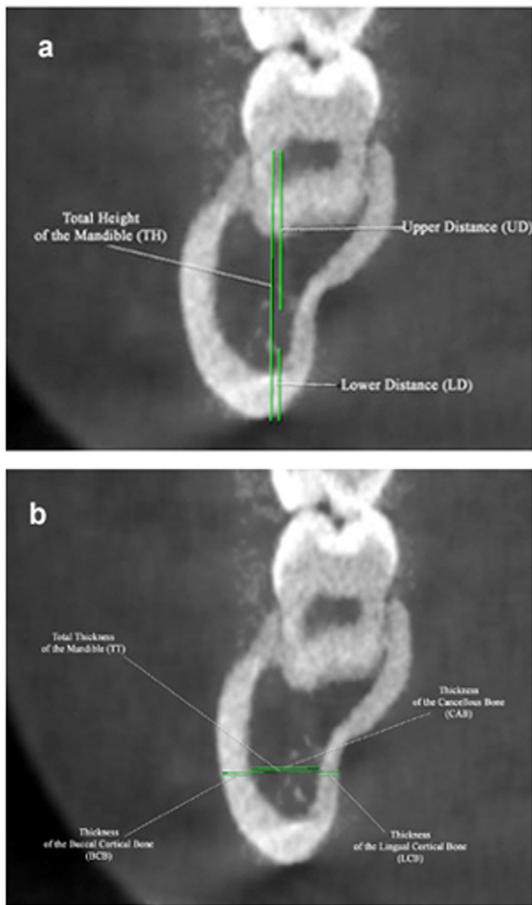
CBCT image of the mandible (coronal section opposite the first molar) showing both vertical (a) and transverse (b) measurement of the mandible.
